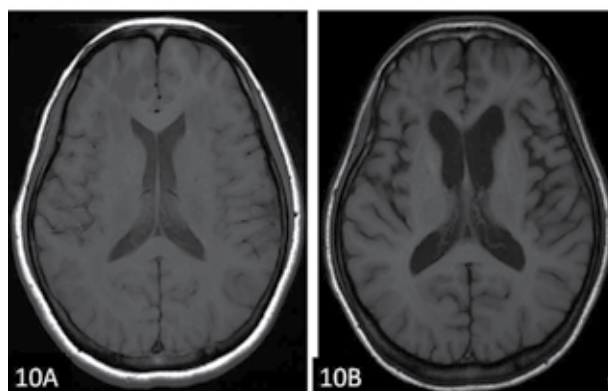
Cortical atrophy after carbon monoxide intoxication revealed in T1-weighted image.
